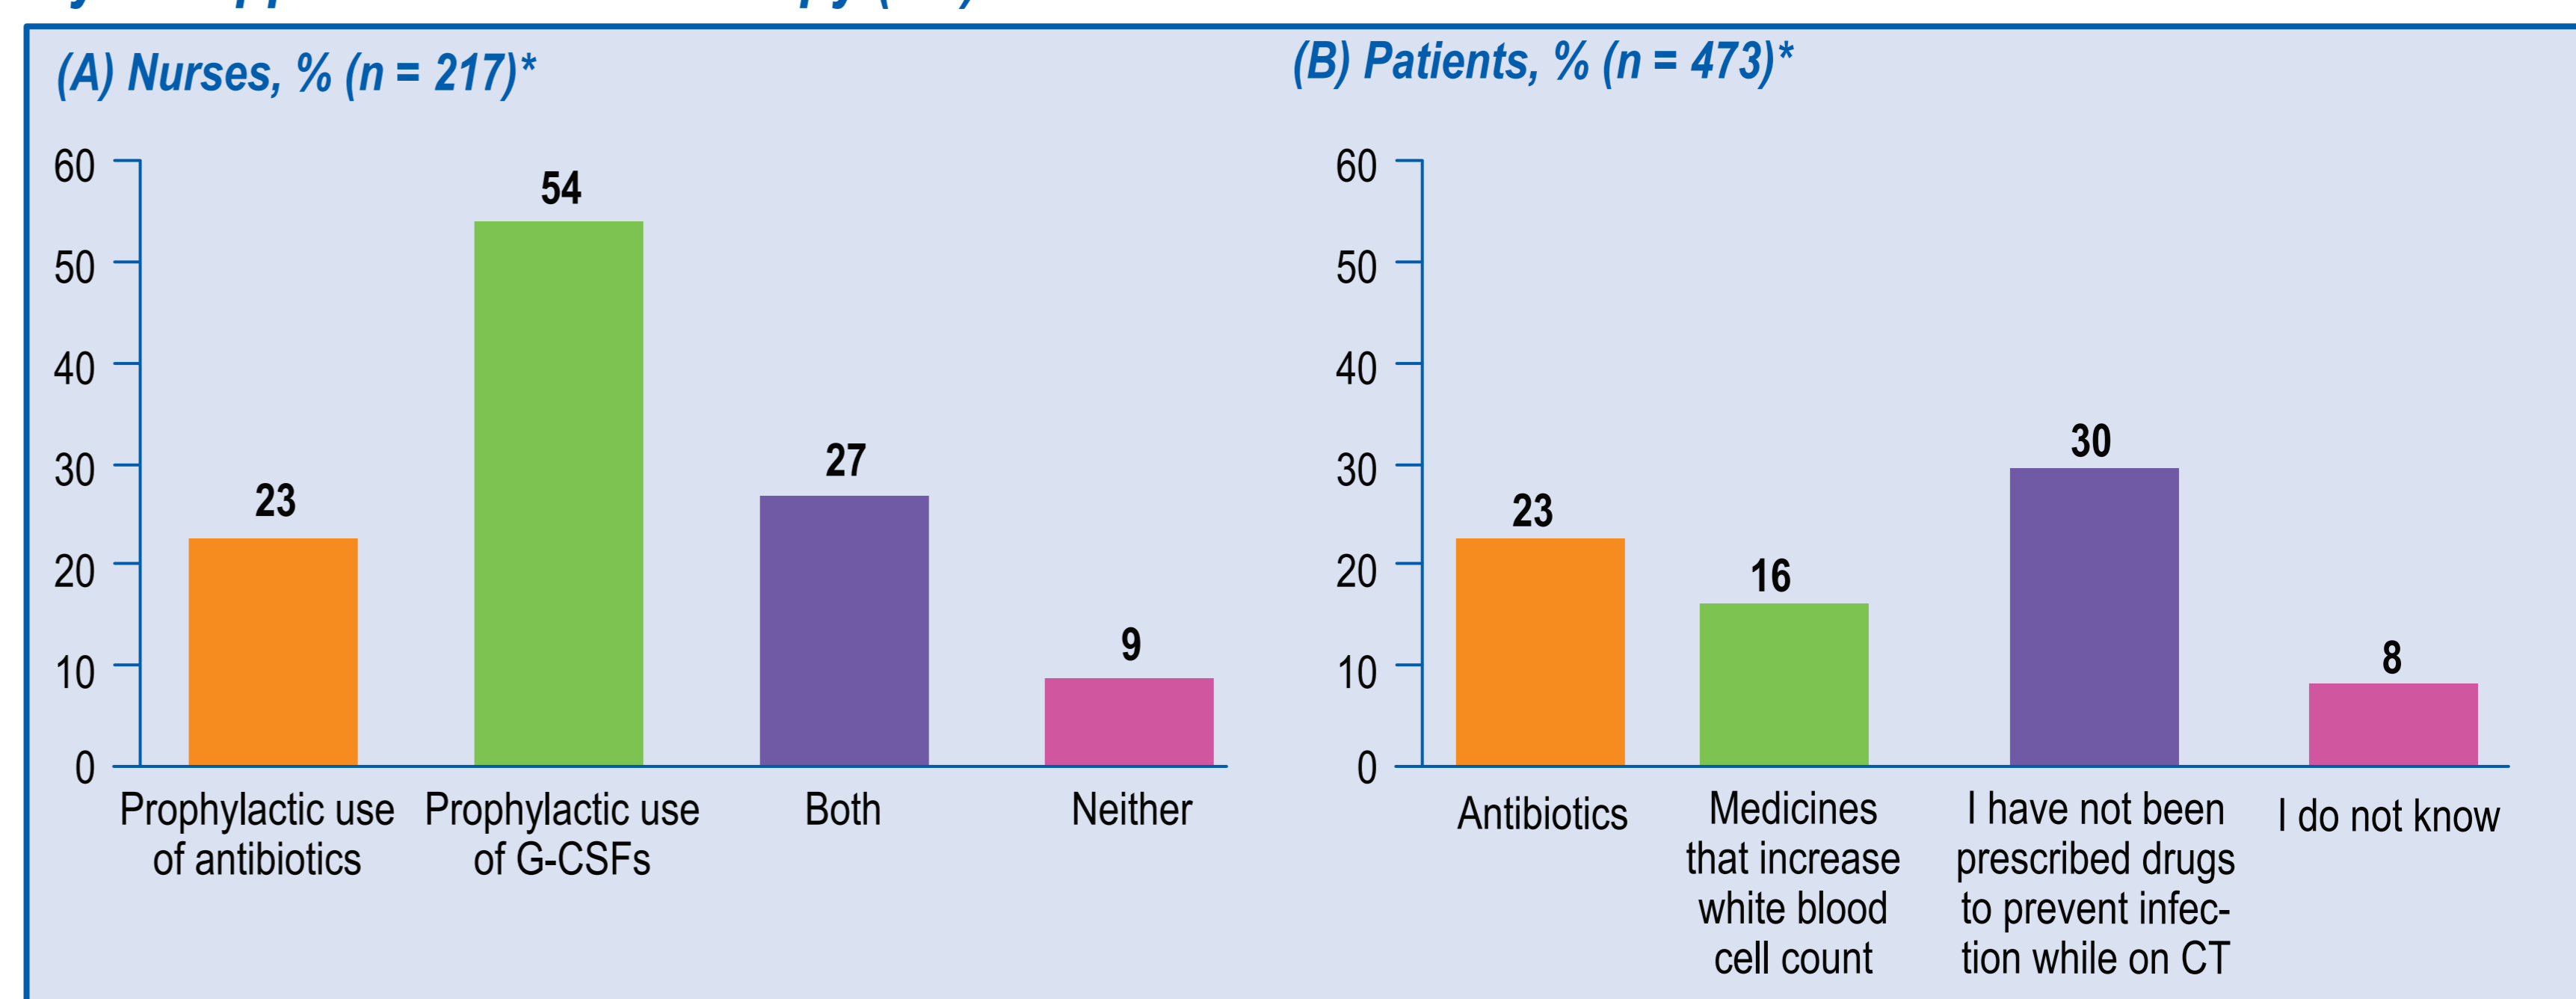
Use of Medication to Reduce Febrile Neutropenia or Infection in Patients Undergoing Myelosuppressive Chemotherapy (CT)
